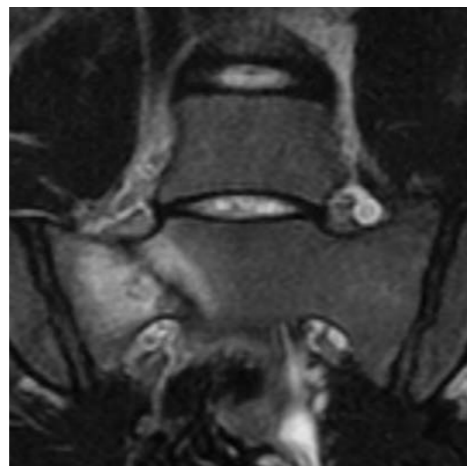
MRI Coronal T2 fat suppressed. Right sacral stress fracture with surrounding marrow oedema.
